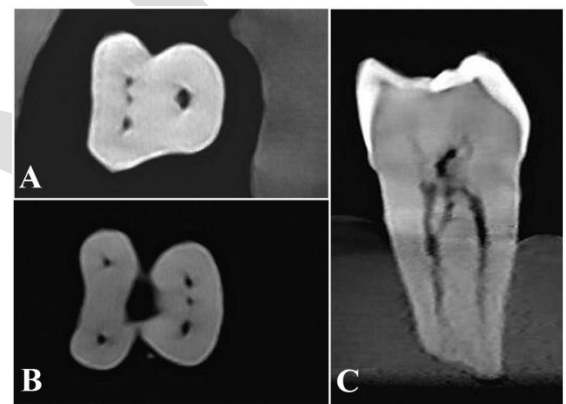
CBCT of MM canals (A&B) in the axial view, (C) coronal view
